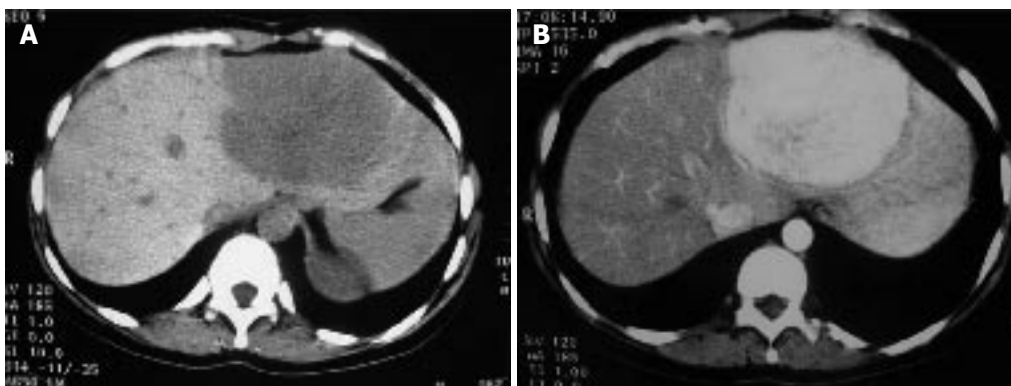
A: Pre-contrast CT scan 3 mo later, revealing the significant increase in the size of the lesion located in the left liver lobe; B: Post-contrast image at the same level showing the increased contrast uptake of the lesion.
